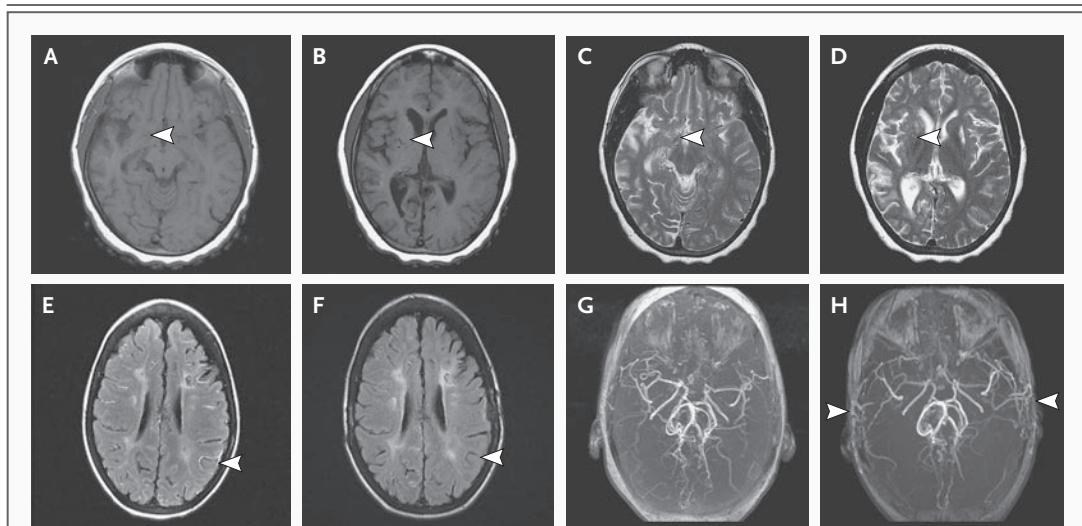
MRI Findings in Moyamoya.
